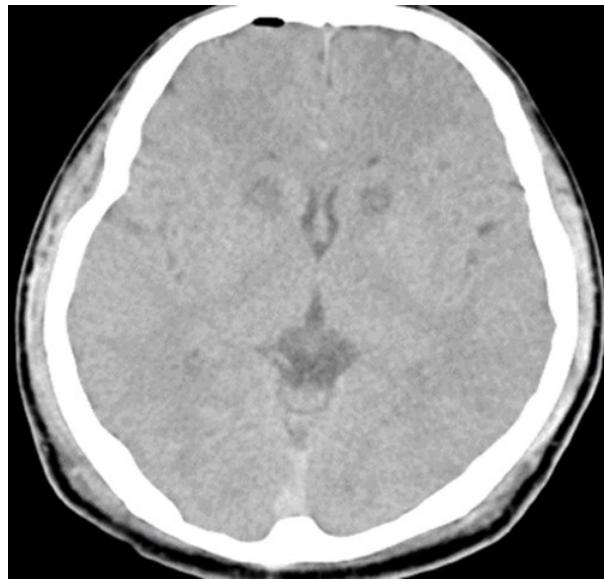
妄想性障碍内囊前肢毁损术后 CT 显示毁损位置准确
